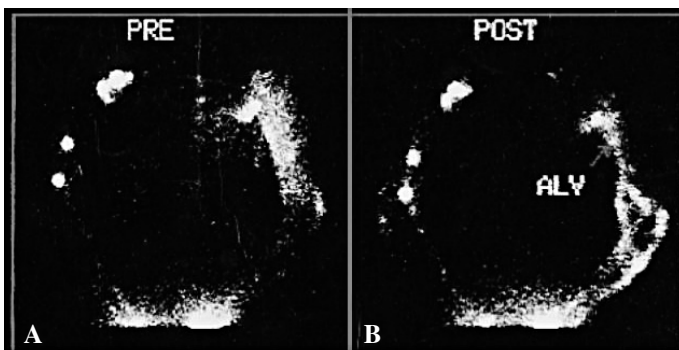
Usefulness of lymphoscintigraphy in the long term assessment of the patency of ve lymphatic-venous derivatmicroanastomoses, before (A) and after (B) microsurgery.
